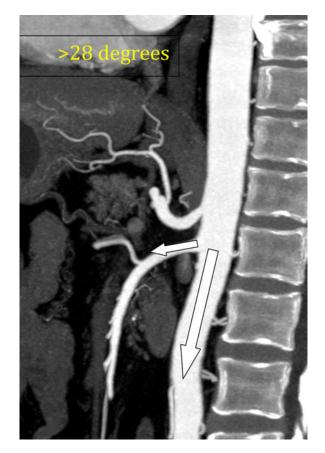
Sagittal contrast-enhanced MIP CT image demonstrating a normal aortomesenteric angle.
